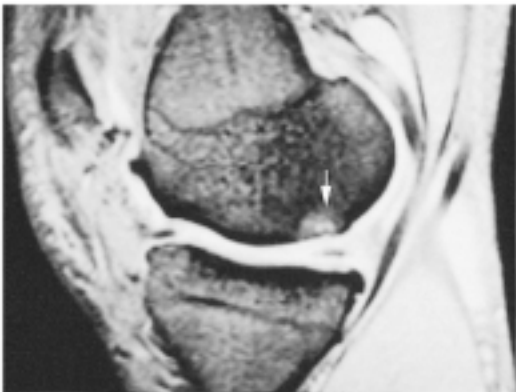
Sagittal T2\*-weighted MR image showing arthritis and cartilage degeneration (grade 3), most evident opposite the posterior horn of the sutured medial meniscus (arrow). This is a localized area of avascular necrosis in the subchondral bone with trabecular bone resorption (arrow).
